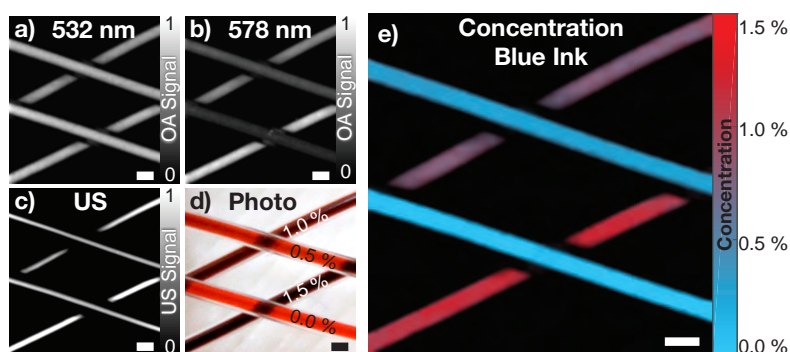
Dual wavelength optoacoustic imaging of ink-filled tubes, validating the spectral unmixing capabilities of the system. (a) & (b) Optoacoustic images recorded at 532 nm and 578 nm, respectively. (c) Corresponding ultrasound pulse-echo MIP image. (d) Photo of the ink-filled tubes, indicating concentration of blue ink in the red-blue ink solution. (f) Mapping the blue ink concentration using the dual-wavelength linear unmixing method. Scale bars - 500 μm . Reproduced with permission from [27]. © Wiley-VCH.
